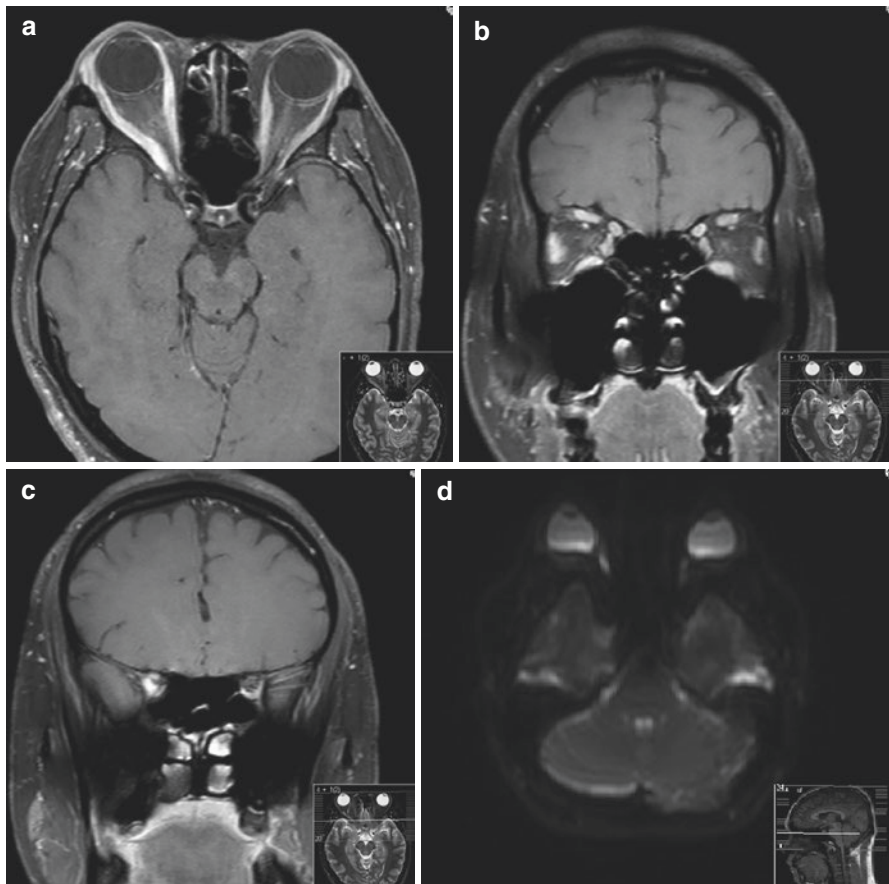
T1 weighted axial and coronal MRI following contrast injection: (a, b, c): there is a mild proptosis on the right side. There is enlargement of the right lateral and medial rectus muscles which exhibit high signal intensity. Note that the tendon insertions are also involved. There are less marked changes in the other muscles on the right and also on the left. The superior ophthalmic vein is dilated. The optic nerve – sheath complex also exhibits high signal. ADC map (d), showing of the orbit showing restricted diffusion within the right lateral rectus muscle
